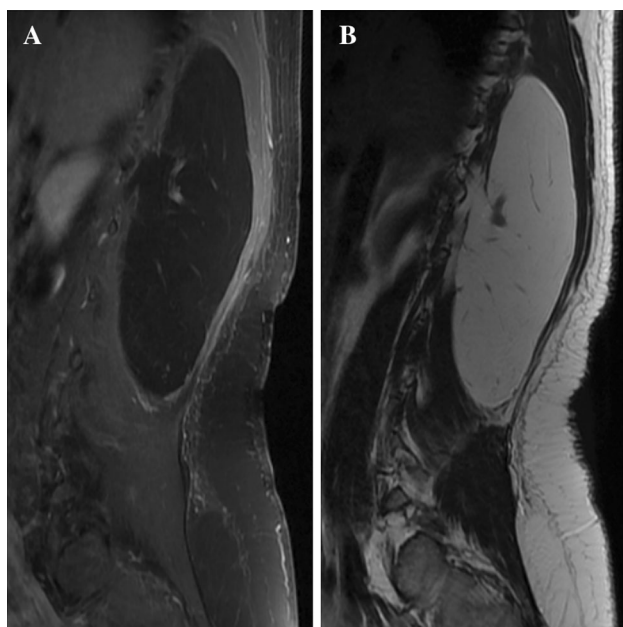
a Parasagittal view with fat suppression showing residual hyperintensity within the tumor. b T1-weighted parasagittal view on the lesion long axis
